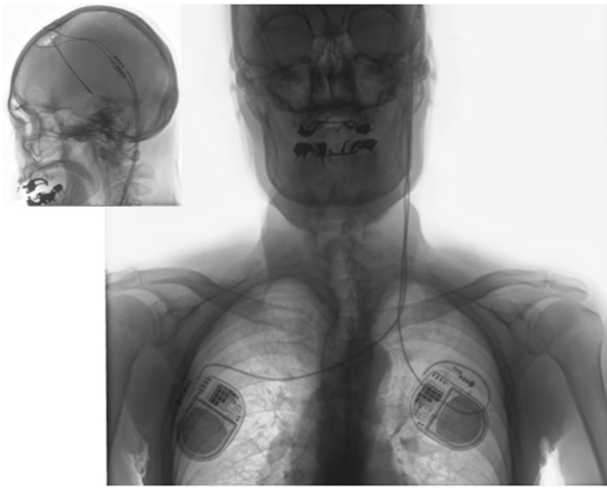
Chest and skull radiographs showing the neurostimulation devices with their electrodes.
